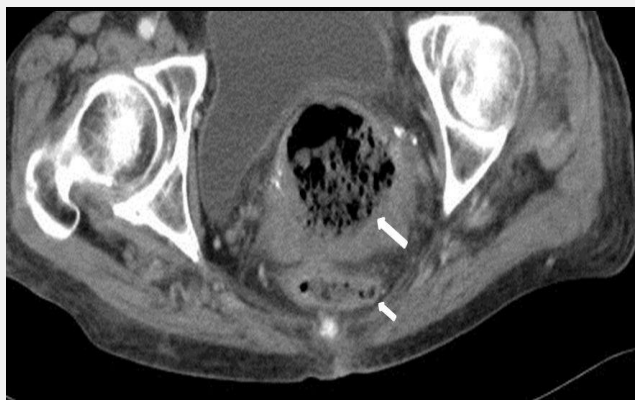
Axial view of patient's abdominopelvic computed tomography.
